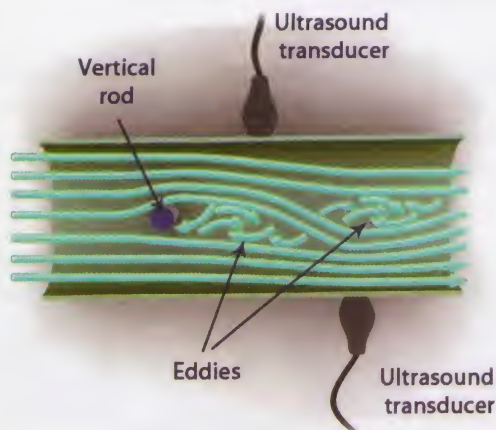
Ultrasonic flowmeter
